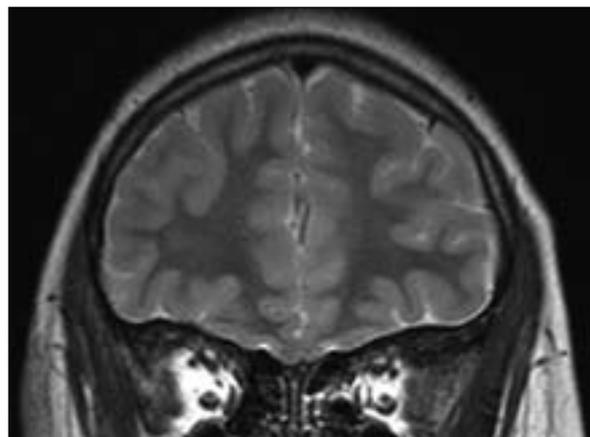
T2-weighted magnetic resonance imaging of the patient's brain
